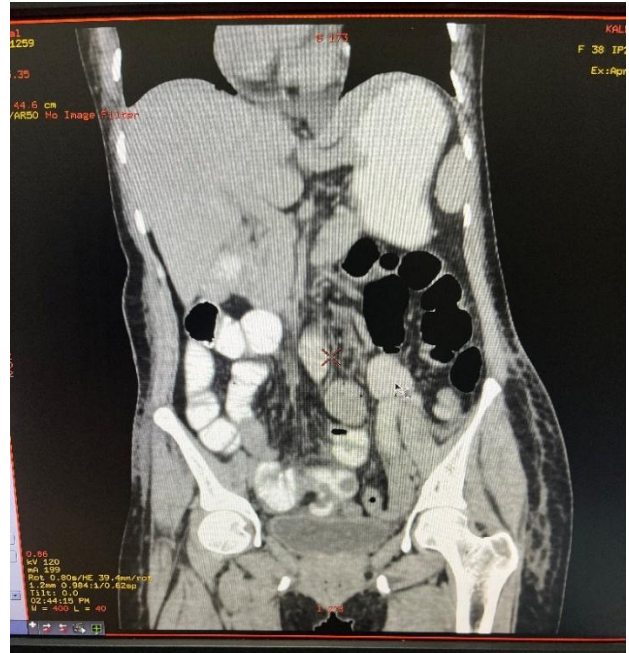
Alignment of the bowel in CT scan.
